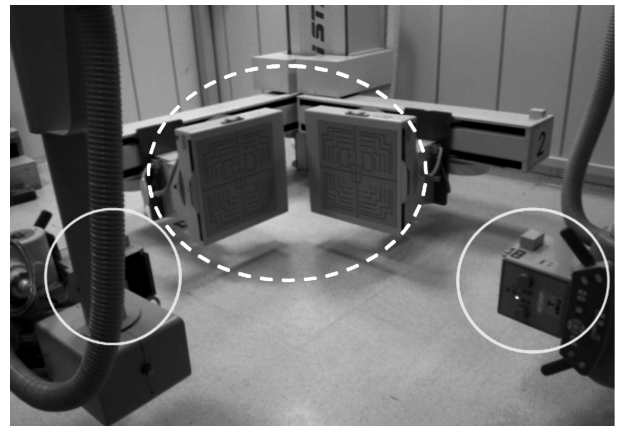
X-ray sources (solid line) synchronized and digital flat-panels (dashed line) for RSA.
